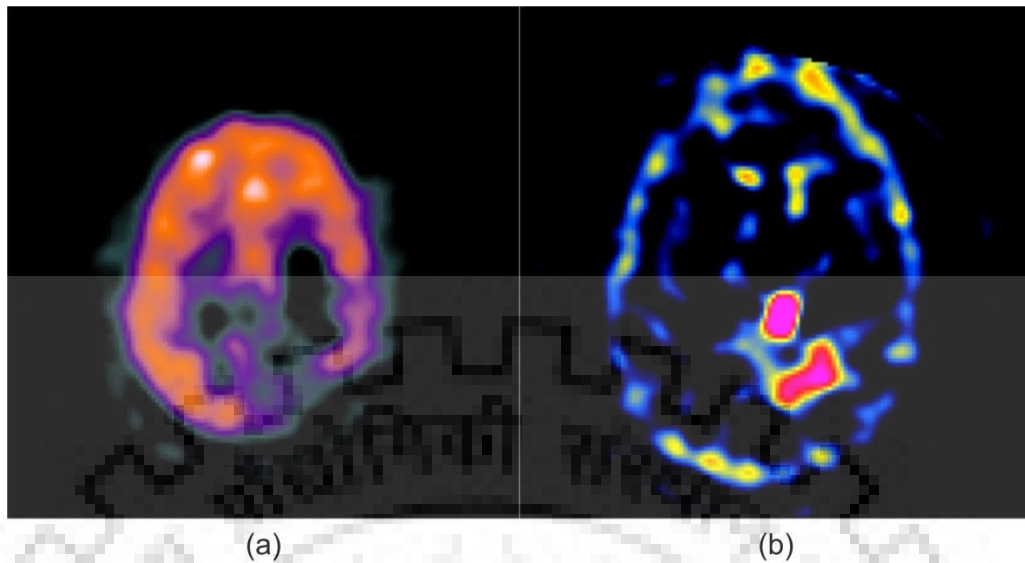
SPECT image made with (a) Technetium (Tc) (b) Thallium (TI)
